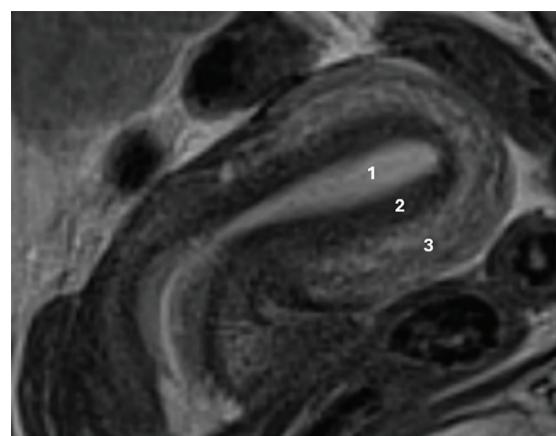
Example of JZ-MRI ReproClass A: a sharply demarcated, homogeneous low-signal intensity band on T2-weighted image, involving less than one-third of the total myometrial thickness (1; Endometrium, 2; junctional zone, 3; Outer myometrium). JZ-MRI: junctional zone- magnetic resonance imaging.
